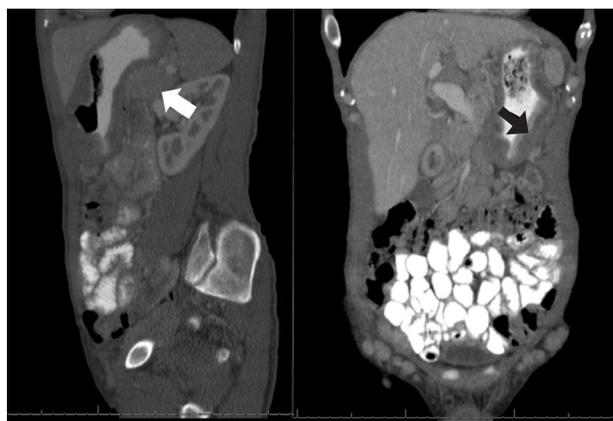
Computed tomography scan of the abdomen and pelvis. The white arrow shows the spleen pressing on the posterior wall of the stomach. The black arrow demonstrates a grossly thickened gastric wall.
